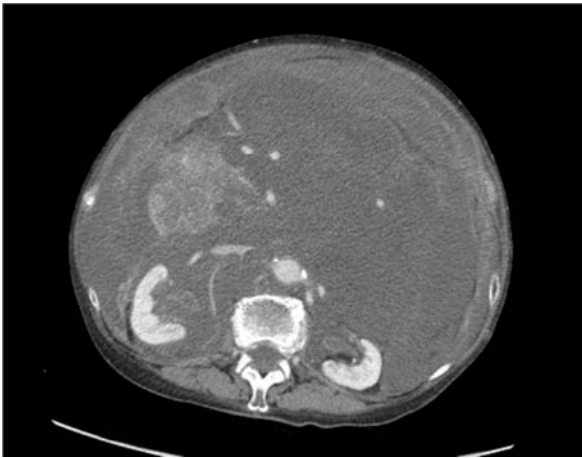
Repeat CT Abdomen/Pelvis (3/2021) with evidence of ill-defined soft tissue with nodularity, concern for carcinomatosis, and large volume ascites.
